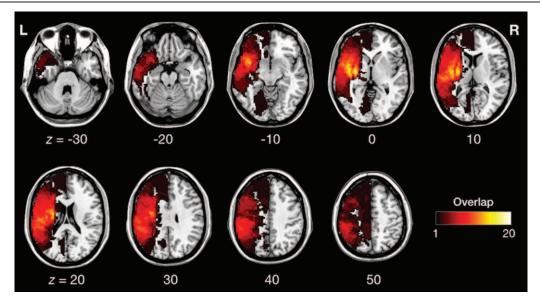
Overlap map showing the lesion location in the 50 patients with stroke. A T1-weighted template is used to demarcate the lesions of each patient. Warmer colors indicate greater lesion overlap. z, Montreal Neurological Institute z coordinates (units: number of patients with a lesion in this region).
